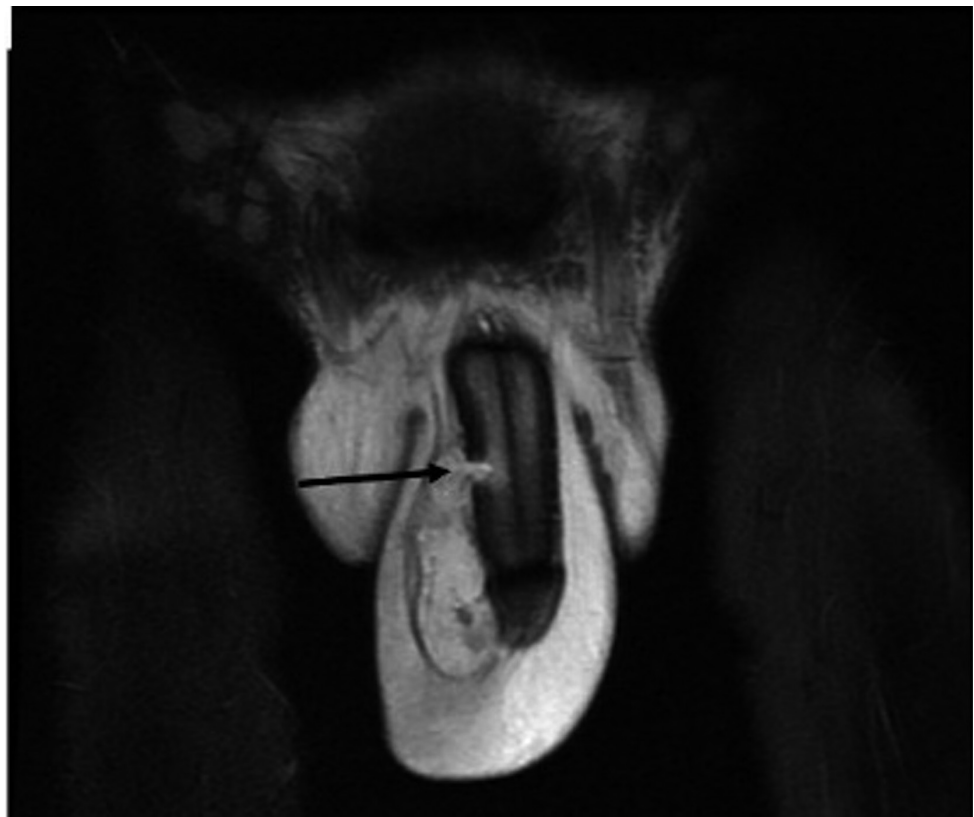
Magnetic resonance imaging coronal T2 image depicting a hyperintense breach of the tunica albuginea as a result of a right-sided distal penile fracture.
